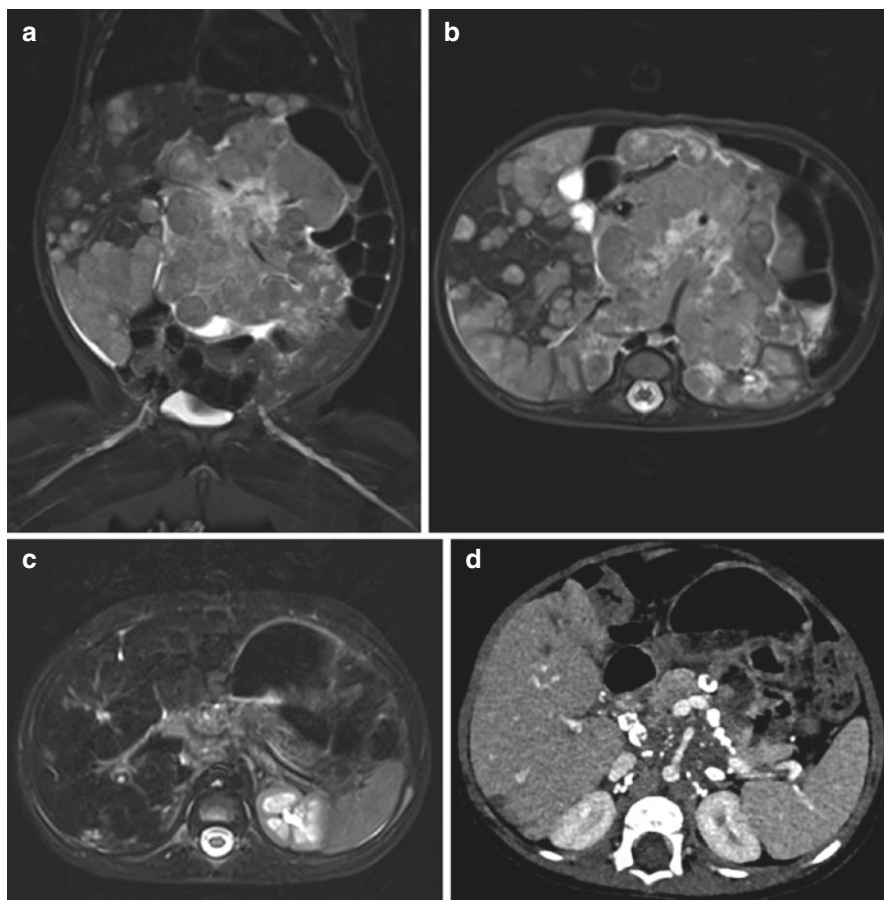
(a) Coronal T2W image showing numerous liver metastases (the darker liver signal is normal liver) with a central abdominal mass in a 2-year-old. (b) Axial T2W image in the same patient better depicting the central abdominal mass which is encasing the aorta and superior mesenteric artery. (c) Follow-up MRI at day 70. There has been considerable tumour shrinkage and the mass is less conspicuous than at diagnosis. (d) Contrast-enhanced CT done at the same time, for surgical planning purposes, reveals widespread calcification in the residual tumour, which was not apparent on the MRI
